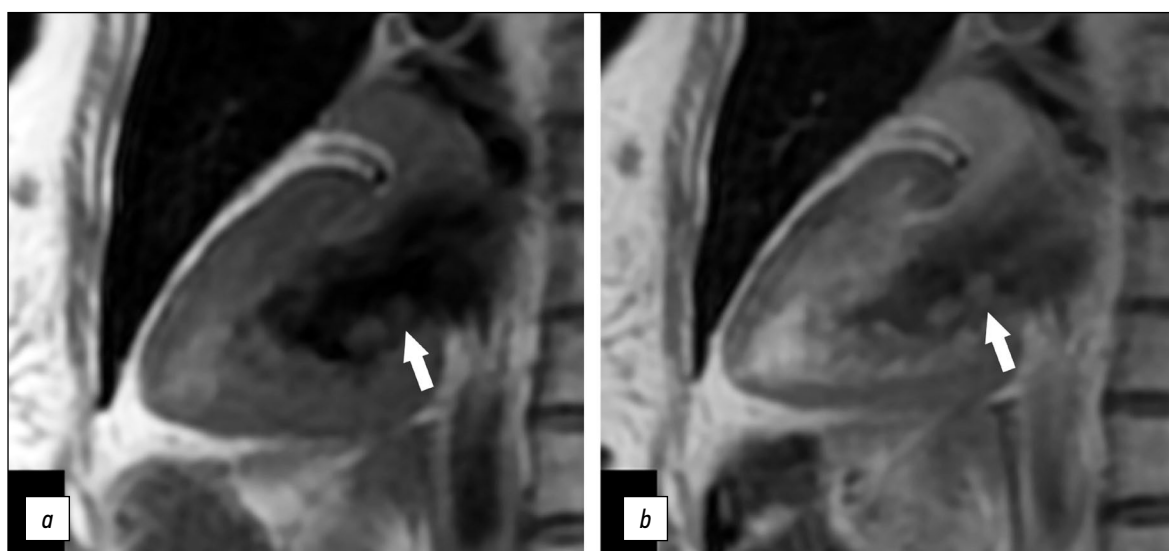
Magnetic resonance imaging of the heart, two-chamber view: *a*, native T1-WI series, TSE; *b*, postcontrast T1-WI series, TSE. Additional mass on the posterior mitral valve leaflet (white arrows).
